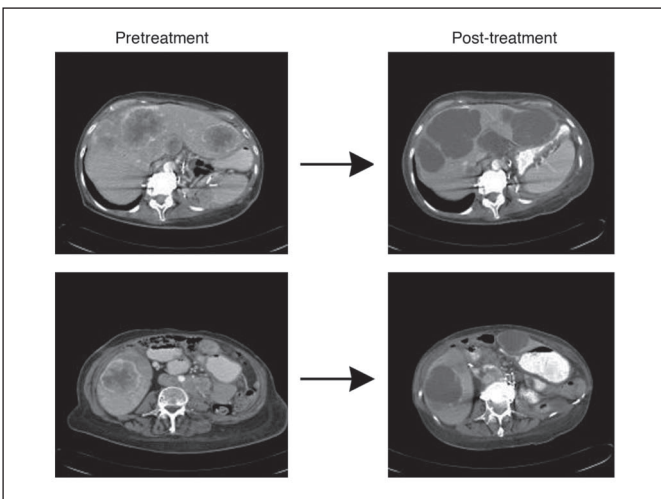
Tumor responses of hepatic metastases: Computed tomography scan images through the liver of a patient after one cycle of treatment with SU11248. Before treatment, several hepatic metastases are apparent. After the first cycle of treatment, the lesions demonstrate lack of enhancement and marked low attenuation consistent with tumor necrosis.
